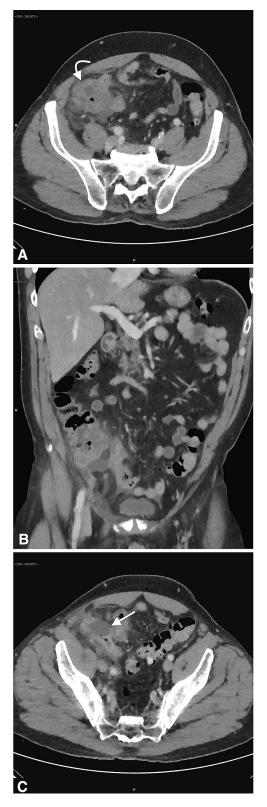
Caecal pole thickening from appendicitis. Axial (A) and coronal (B) CT images showing marked edema and thickening of the caecal pole (*curved arrow*) with surrounding inflammatory fluid and fat stranding. (C) Axial CT images, inferior to the previous level, showing an inflamed thickened appendix with deficiency to the anterior wall at the base, consistent with perforation (*arrow*).
